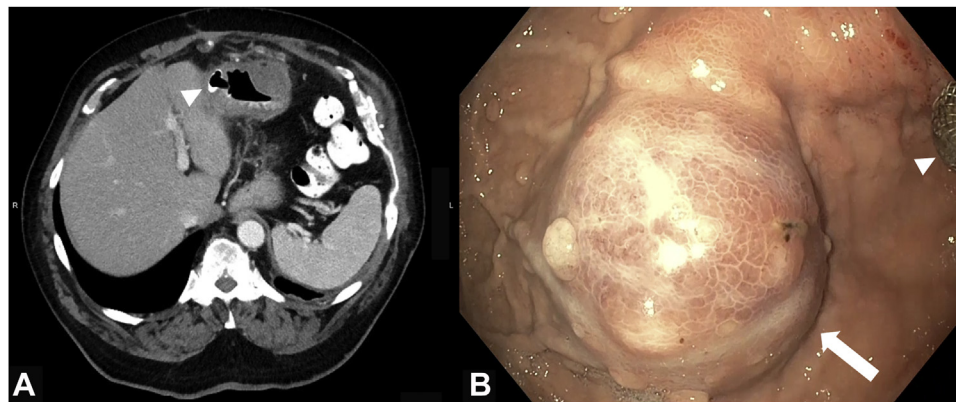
Presence of second gastric intramural abscess. A, Despite initial lumen-apposing metal stent placement (*arrowhead*), repeat CT demonstrated the presence of a gastric intramural abscess. B, Repeat endoscopy confirmed the presence of a second gastric intramural abscess (*arrow*) not drained by the original lumen-apposing metal stent (*arrowhead*).
